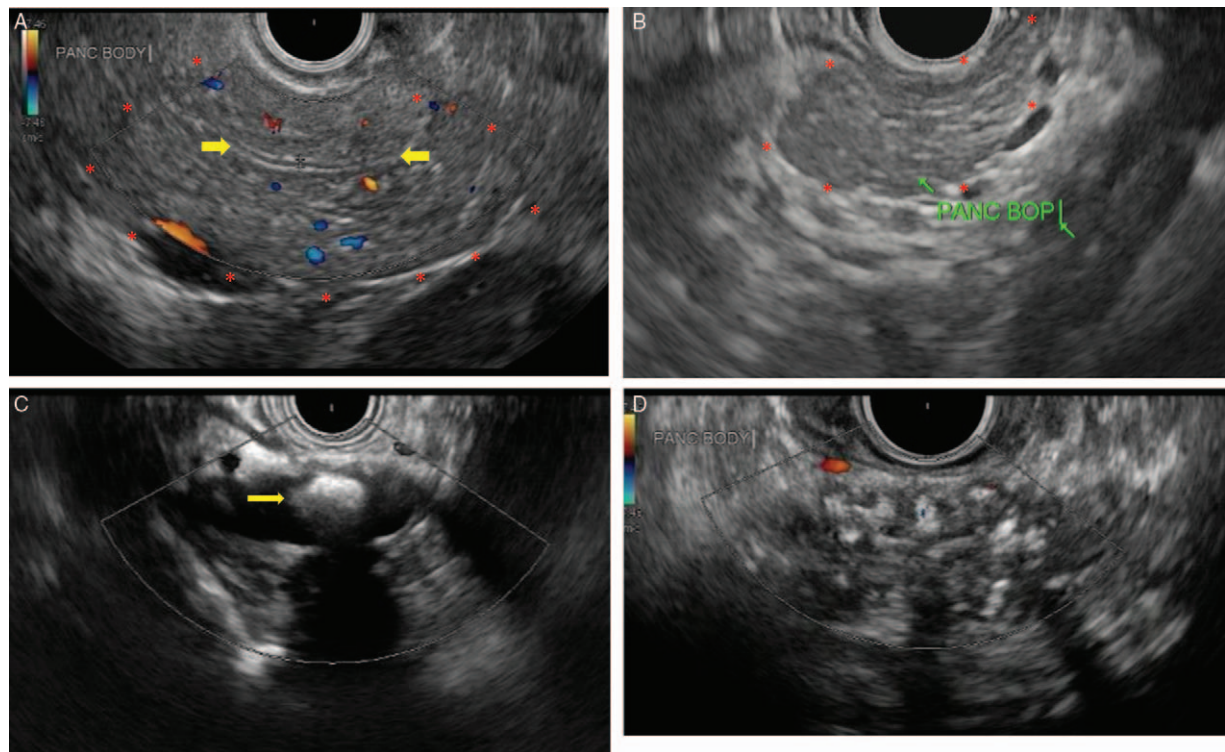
Endoscopic ultrasonography. (A) EUS with Doppler image of a 13-year-old with a normal pancreas duct (bracketed by yellow arrows) and pancreas parenchyma (outlined by red asterisks). (B) EUS image of a 4-year-old demonstrating normal body of pancreas parenchyma (outlined by red asterisks). (C) EUS image of a 16-year-old with cystic fibrosis transmembrane conductance regulator, who has a pancreatic duct calculi (arrow) with shadowing effect. (D) EUS imaging of a 7-year-old with calcific pancreatic parenchyma as demonstrated by shadowing hyperechoic foci. EUS = endoscopic ultrasonography.
